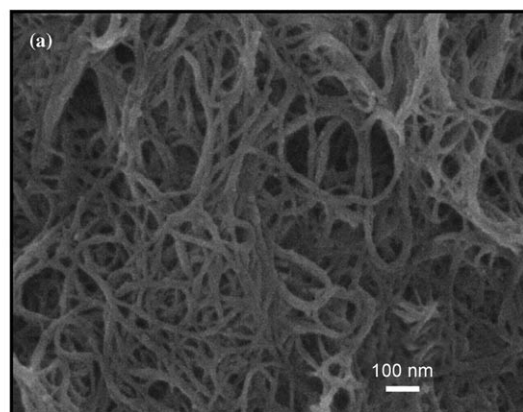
a) SEM image of a SWNT bucky paper. b) Effect of added volume of 1-pyrenemethylamine hydrochloride (PMA) on the amount of calf-thymus DNA (CT-DNA) adsorbed per mg of the SWNT bucky paper. The volume of PMA (10 mM in methanol) was varied from 0 to 6 mL (0–60 µmol PMA) and 0.7 mg of SWNTs were used. The adsorbed DNA was first washed twice with buffer (50 mM Tris buffer, pH 7.0) followed by two washes with buffer-containing salt (50 mM Tris buffer, pH 7.4, plus 0.6 M NaCl) to yield the DNA that remained adsorbed following washing. The loading of CT-DNA adsorbed on the bucky paper was calculated by a mass balance.
